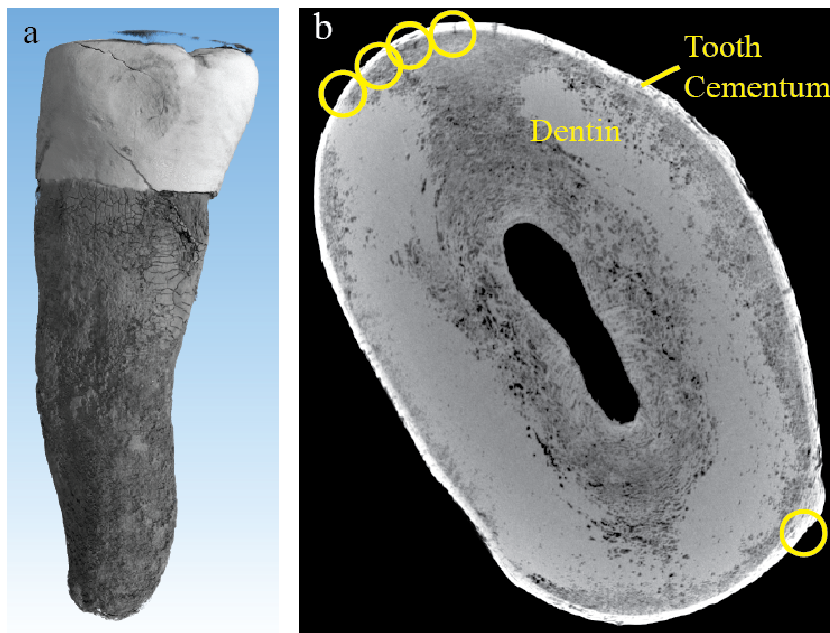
(a) 3D rendering of the complete tooth from the conventional  $\mu$ CT scan and (b) a selected reconstructed slice from the conventional  $\mu$ CT. The yellow-colored circles indicate the positions of the high-resolution tomography performed at the synchrotron radiation facility.
